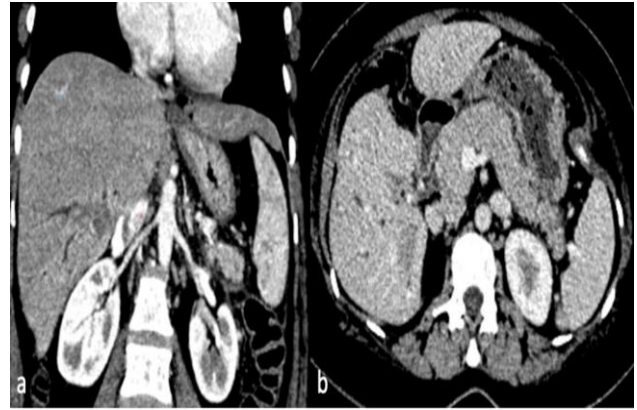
(A and B): Coronal and axial sections of contrast enhanced CT of the abdomen in the portal venous phase show intrahepatic extension of the mass involving segment VI of the right lobe. Note normal pancreatic attenuation and enhancement and the absence of pancreatic duct dilatation.
